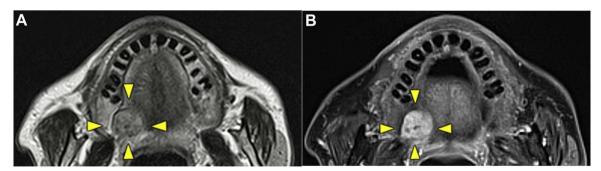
Horizontal magnetic resonance imaging scans. A: T2-weighted image showing a tumor with an inhomogeneous center (arrow). B: Contrast-enhanced T1-weighted image showing tumor with non-uniform contrast effect (arrow).
